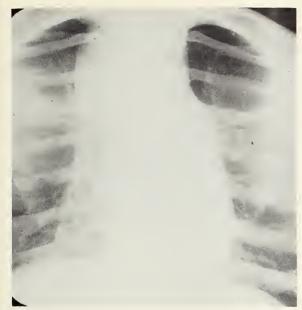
Posteroanterior chest x-ray (in lordotic position) showing a bilateral paratracheal mass in the upper mediastinum more prominent on the right side.
